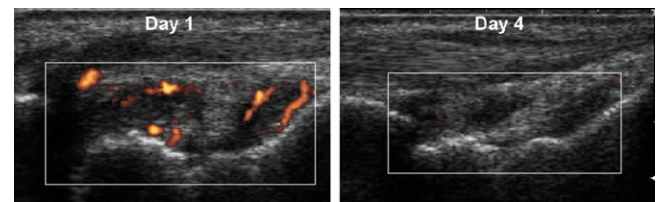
Ultrasonography with power-Doppler of the right wrist (Patient n° 1). At day 1, mode B ultrasound revealed synovial hypertrophy with hypervascularisation in power-Doppler. After 3 days of anakinra, ultrasonography showed a decrease of the synovial hypertrophy and no vascularisation in power-Doppler.
